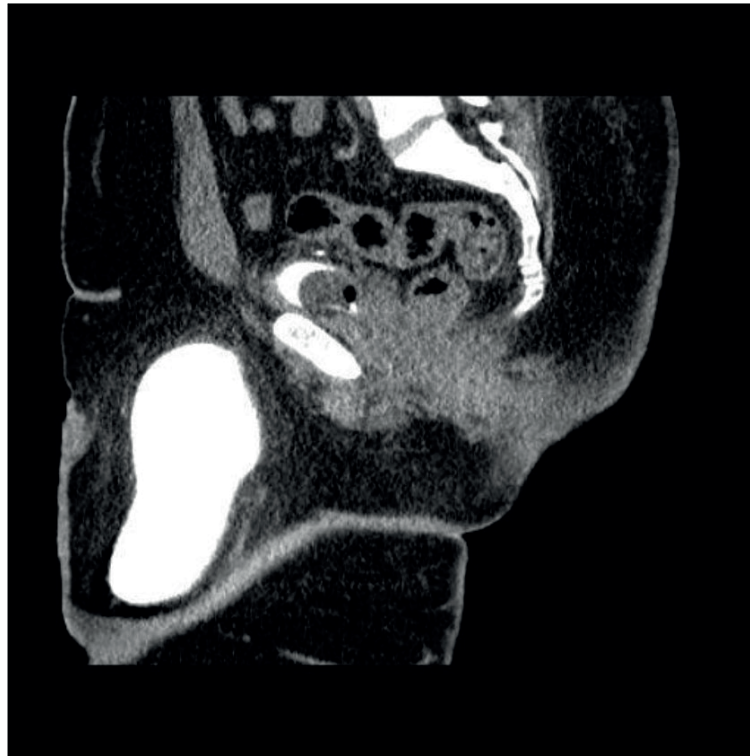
Delayed CT-IVU; left-sided ureter is dilated and herniated into the left inguinal region.
